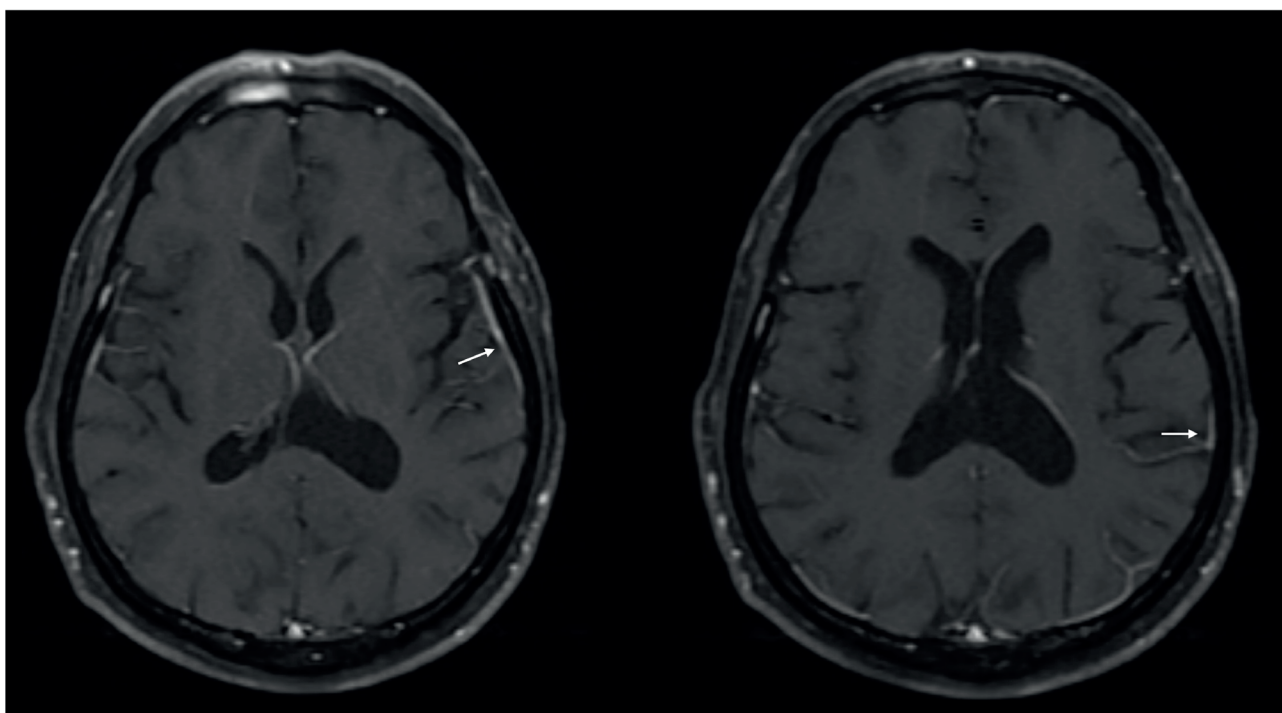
Case-1. Contrast-enhanced MRI of brain. Contrast-enhanced T1-weighted axial image. Showed left parietal leptomeningeal involvement (white arrow).
